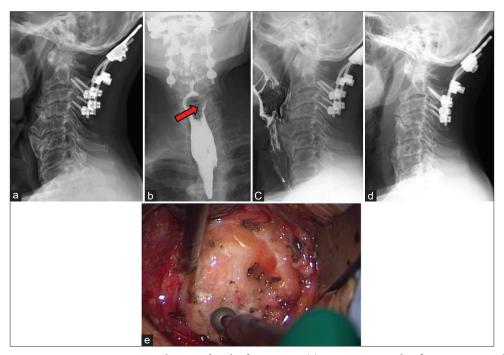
Aggressive OALL is prominent on cervical X-ray after the first surgery (a). Preoperative video fluoroscopy revealed a filling defect due to OALL at the C5/6 level (b,c). The red arrow in Figure 2b indicates contrast loss. Cervical X-ray after OALL resection showing adequate smoothening of the OALL (d). In the operative field, the OALL is flattened with a diamond burr (e).
